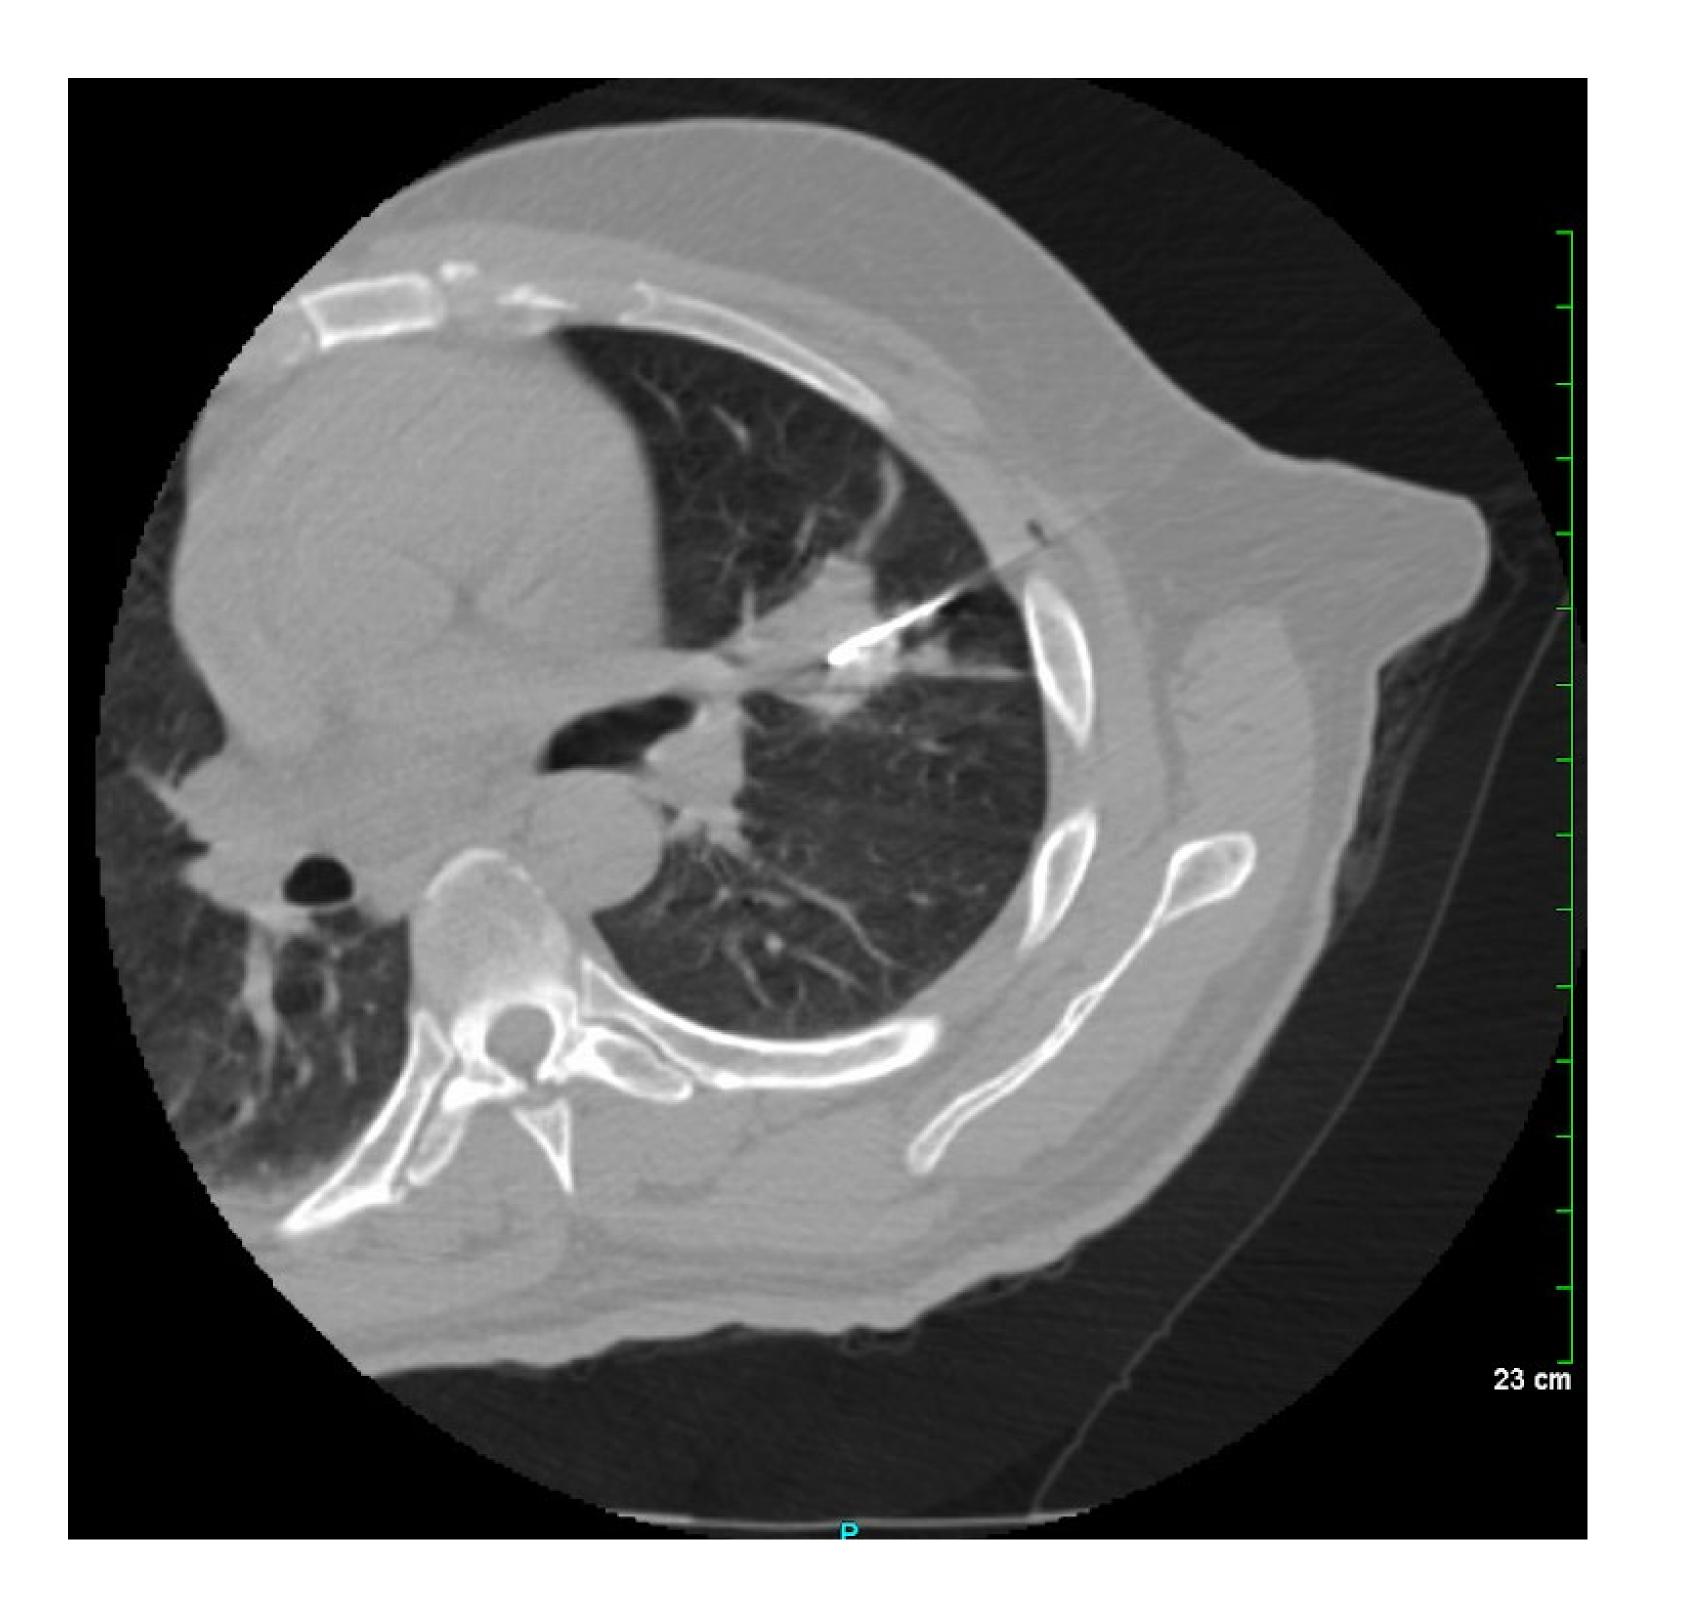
Axial imaging of CT-guided percutaneous lung biopsy of left upper lung mass. Pathology findings demonstrated capsulated fungal organism, consistent with cryptococcus.
